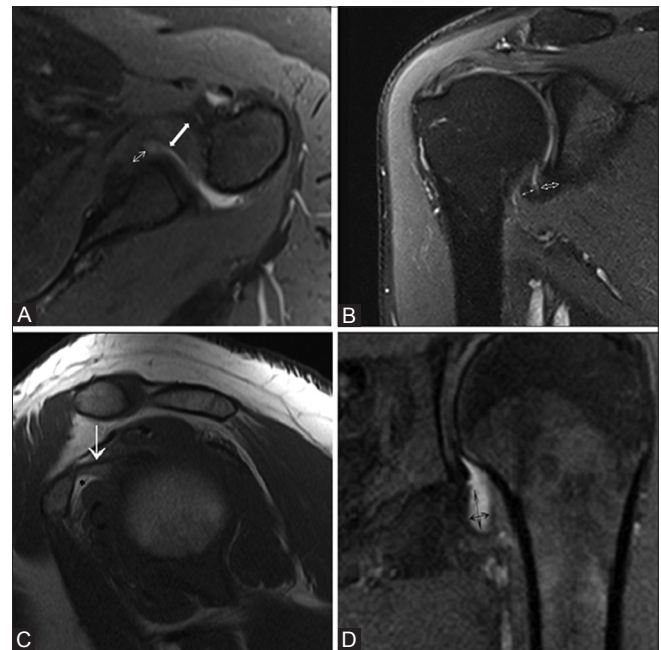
(A-D): (A) Axial proton density (PD) fat-suppressed image shows the measurement of maximal thickness of the humeral (solid arrow) and glenoid portions (line arrow) of the anterior band of inferior glenohumeral ligament (IGHL). (B) Coronal PD fat-suppressed image shows the measurement of maximal thickness of the humeral (solid arrow) and glenoid portions (open arrow) of the IGHL at the midaxillary pouch at the level of glenohumeral joint. (C) Sagittal T1-weighted image shows the coracohumeral ligament (arrow). Normal fat in subcoracoid triangle (asterisk). (D) Coronal PD fat-suppressed image shows the measurement of maximal height and width of the axillary pouch
